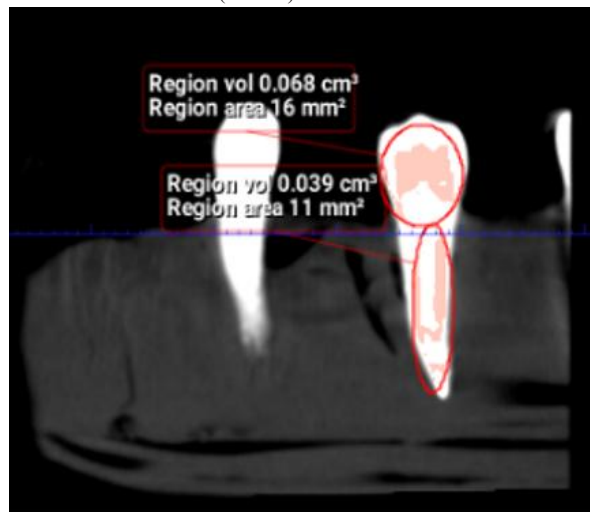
CBCT scanned image showing calculation of surface area (mm²) and volume (mm³)
